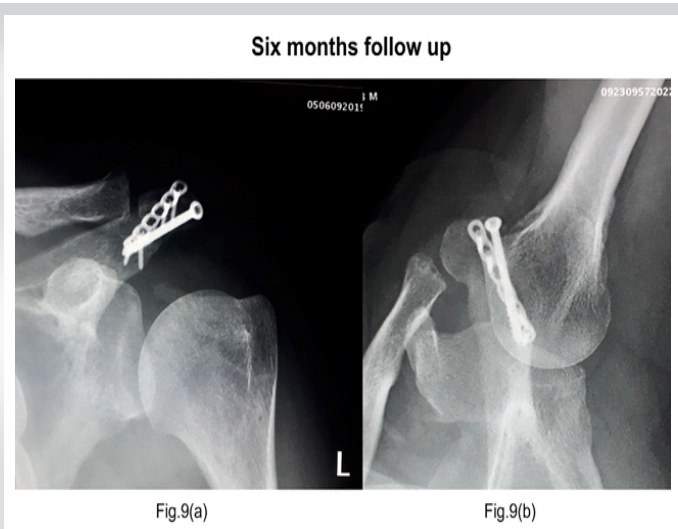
(a and b) Radiographs taken on 6-month follow-up.
